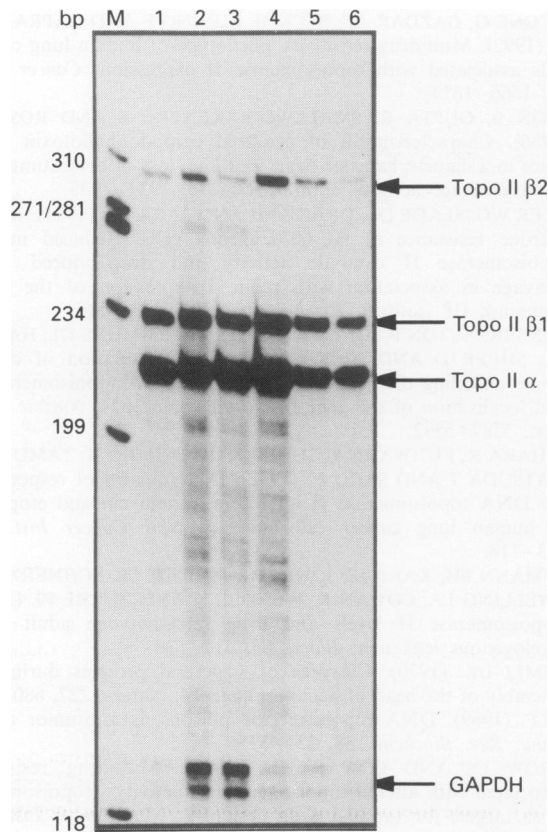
Ribonuclease protection analysis of topoisomerase II α and topoisomerase II β mRNA levels in human breast cancer cell lines. An autoradiogram of an acrylamide gel showing the mobility of RNA species protected from RNAase digestion. Lanes: M, molecular weight standards, as indicated in base pairs on the left; 1, SKBr3; 2, MCF7; 3, T47D; 4, MDA 231; 5, ZR75; 6, MDA 468. The positions of the topoisomerase II α protected fragment and the two alternately spliced topoisomerase II β transcripts (β 1 and β 2) are indicated on the right. The GAPDH-specific protection fragment is also indicated on the right. Densitometric scanning of autoradiograms was conducted when each signal was within the linear range for X-ray film.
